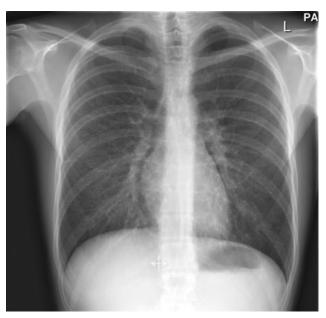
Chest radiograph shows bilateral fine reticular nodular shadowing in both lungs.
